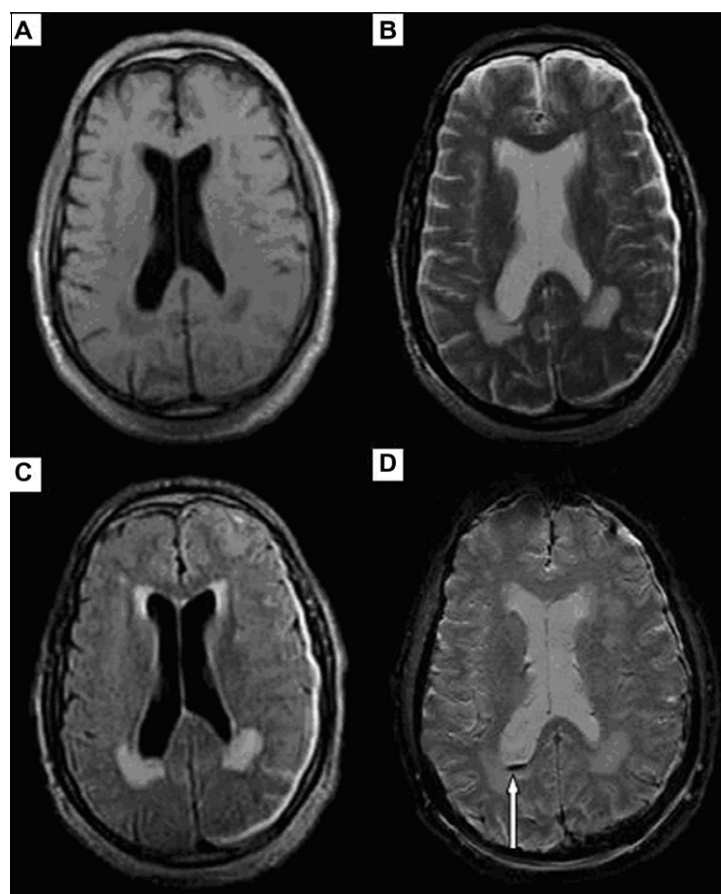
Seventy-three year old hypertensive male patient presenting with altered sensorium. T1 (A), T2 (B) and FLAIR (C) images reveal age matched involuntional brain changes in the form of ectatic ventricles, SWI (D) revealed right intraventricular minimal hemorrhage (arrow).
